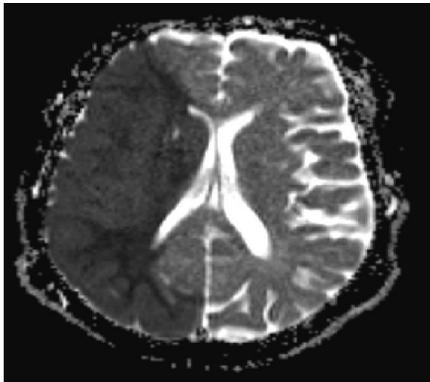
An MRI ADC map of the same area depicted in figure 2 shows a dark signal in the right MCA distribution. Taken with DWI sequence in figure 2, both indicate an acute ischemia in the whole right MCA territory.
